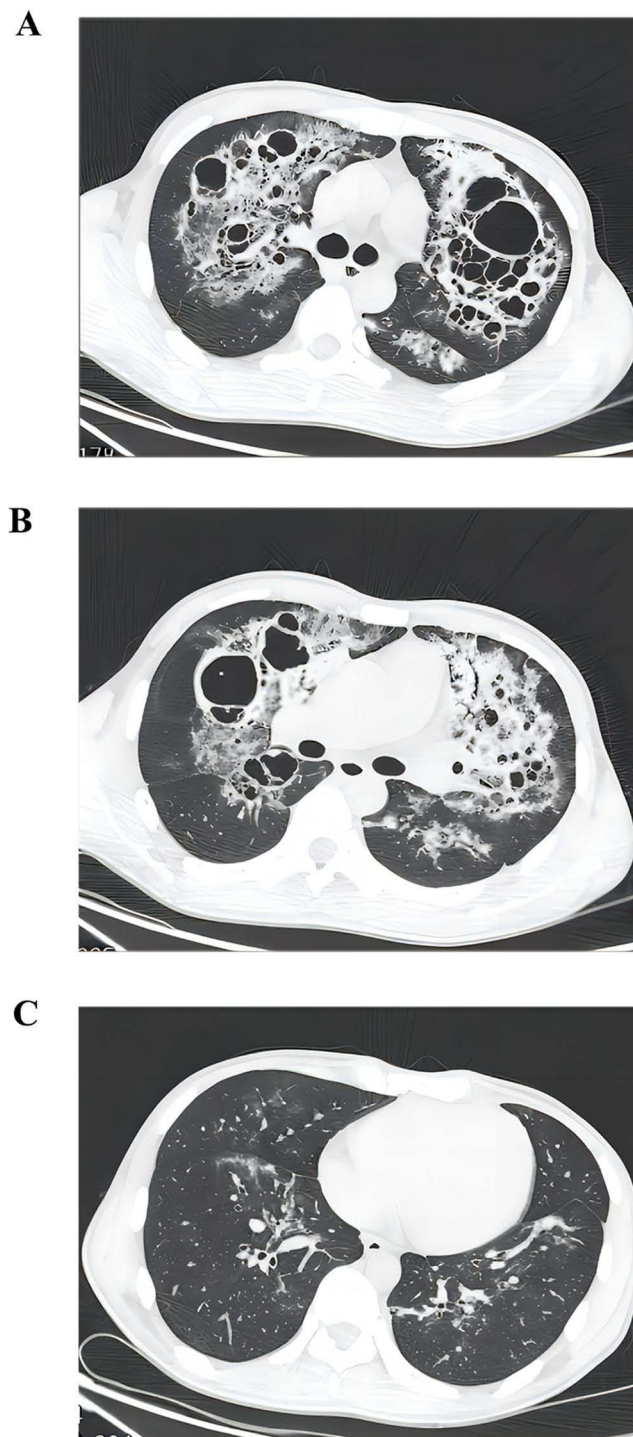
The chest HRCT scan from July 26, 2022, taken at the time of initial diagnosis, shows the patient's lungs with multiple nodular opacities, patchy areas, and honeycombing, predominantly in the upper lobes, characterized by uneven densities and some areas showing lucencies and bronchial images. (A) Tracheal bifurcation level: honeycomb of different sizes and infiltrating patchy shadows can be seen in most areas, with the honeycomb as the main change, (B) The bronchial level of the right middle segment: septal thickening with nodular infiltrates and honeycomb of different sizes, more septal thickening with nodular infiltrates than honeycomb, (C) The bronchial level of the basal segment: The local infiltration shadow was visible in a small area, and the honeycomb was not obvious.
